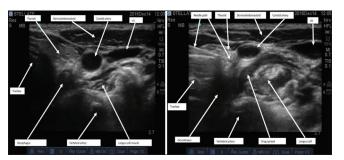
Ultrasound guided stellate ganglion block
